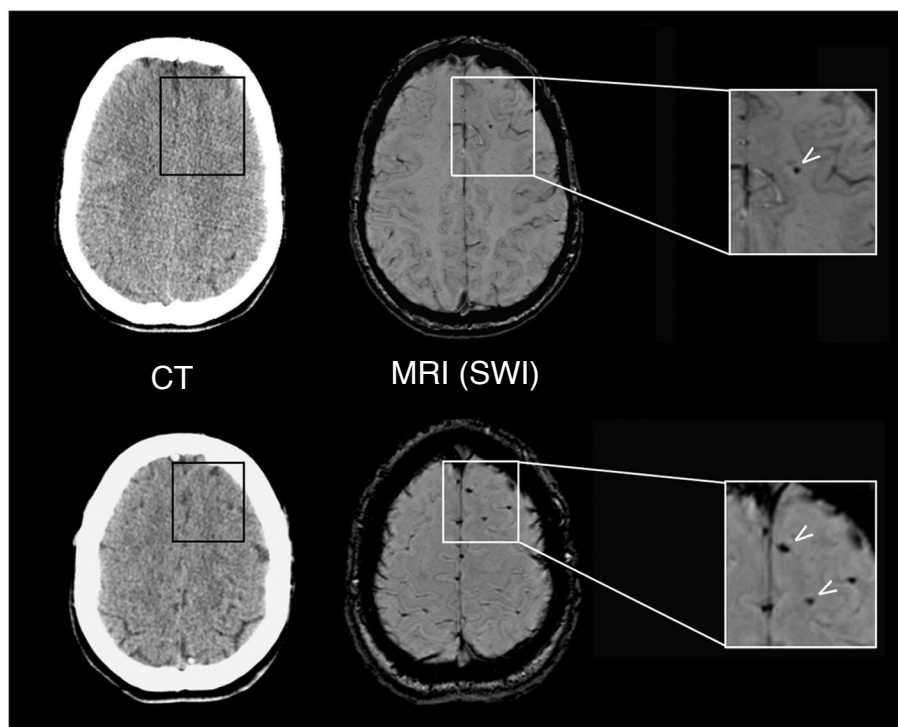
Neuroradiological findings in a 26-year-old patient with mTBI. The results of a brain CT scan (left) performed 2 h after the trauma were normal, whereas a brain MRI study at 10 days (right) revealed focal signal alterations (arrows) on SWI sequences, which corresponded to microbleeds indicative of mild DAI.
